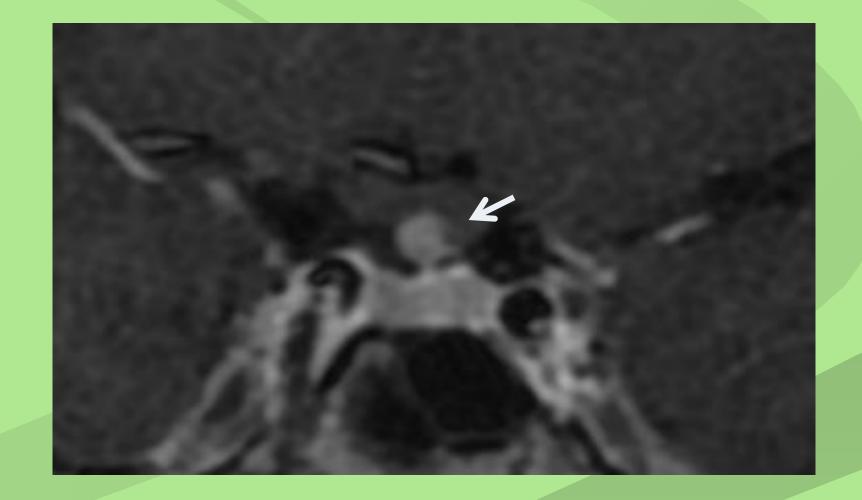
Coronal Pituitary MRI Compression of optic chiasm
